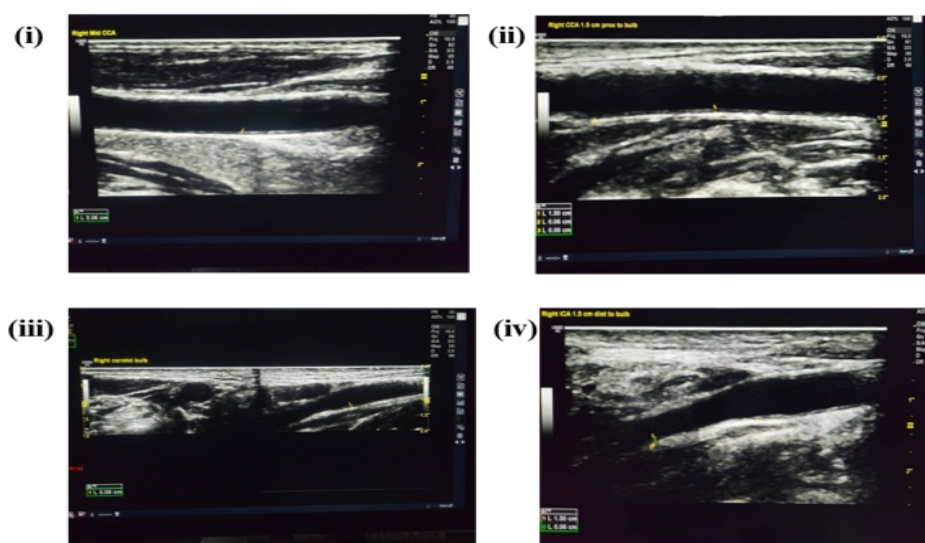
Standardized sites for carotid intima-media thickness (CIMT) measurement on B-mode ultrasonography: (i) Mid common carotid artery (CCA), (ii) CCA approximately 1.5 cm proximal to the carotid bulb, (iii) Carotid bulb, (iv) Internal carotid artery (ICA) approximately 1.5 cm distal to the carotid bulb.
